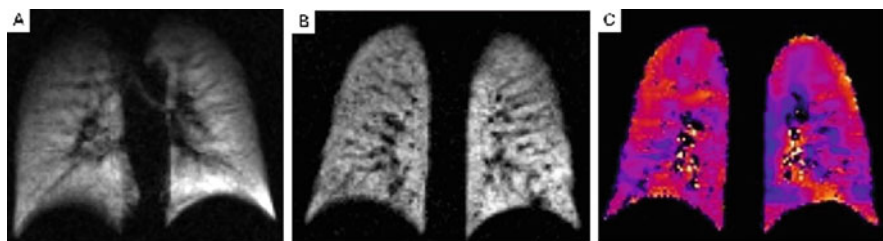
Depiction of lung ventilation using hyperpolarized ^3He MRI. Ventilation images are shown for two slice thicknesses (*left and center panels*), along with a corresponding map of apparent diffusion coefficient (ADC), which relates to dimensions of the lung microstructure and is sensitive to disease states
